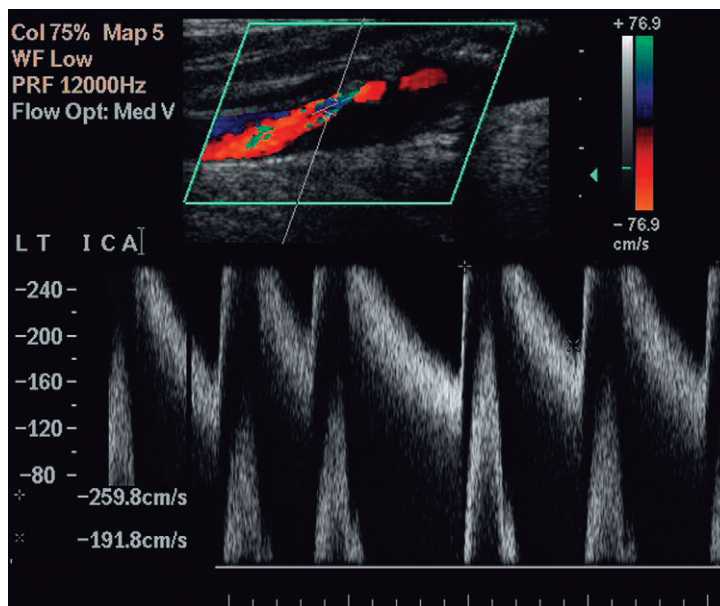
A stenosis of the internal carotid artery showing a peak systolic velocity in excess of 2.6 m s^{-1} and an end-diastolic velocity of 1.9 m s^{-1} . There is aliasing of both the colour and spectral Doppler displays.
